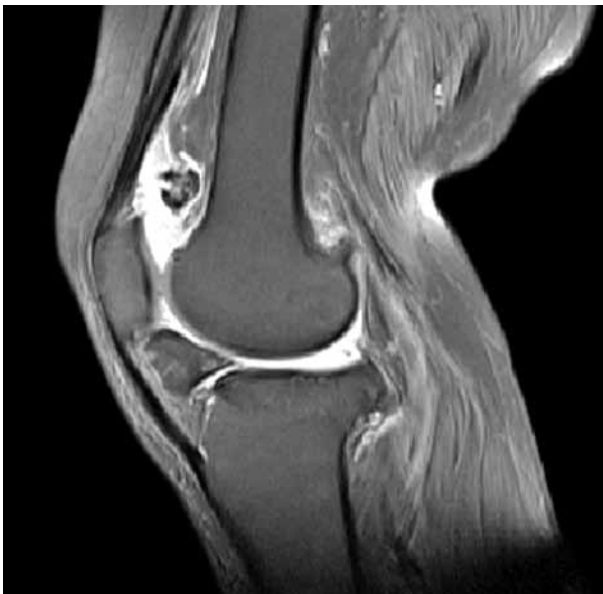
Sagittal T₂-weighted magnetic resonance image of the knee showing distension and distortion in Hoffa's fat pad; a smooth contoured lesion in the infrapatellar fat pad that is hypointense to muscle and isointense to tibia and femur; increased fluid in joint space and suprapatellar bursa; a lesion consistent with loose body in the suprapatellar bursa that is isointense to muscle in the center and hypointense in the periphery; meniscus and knee joint space.
